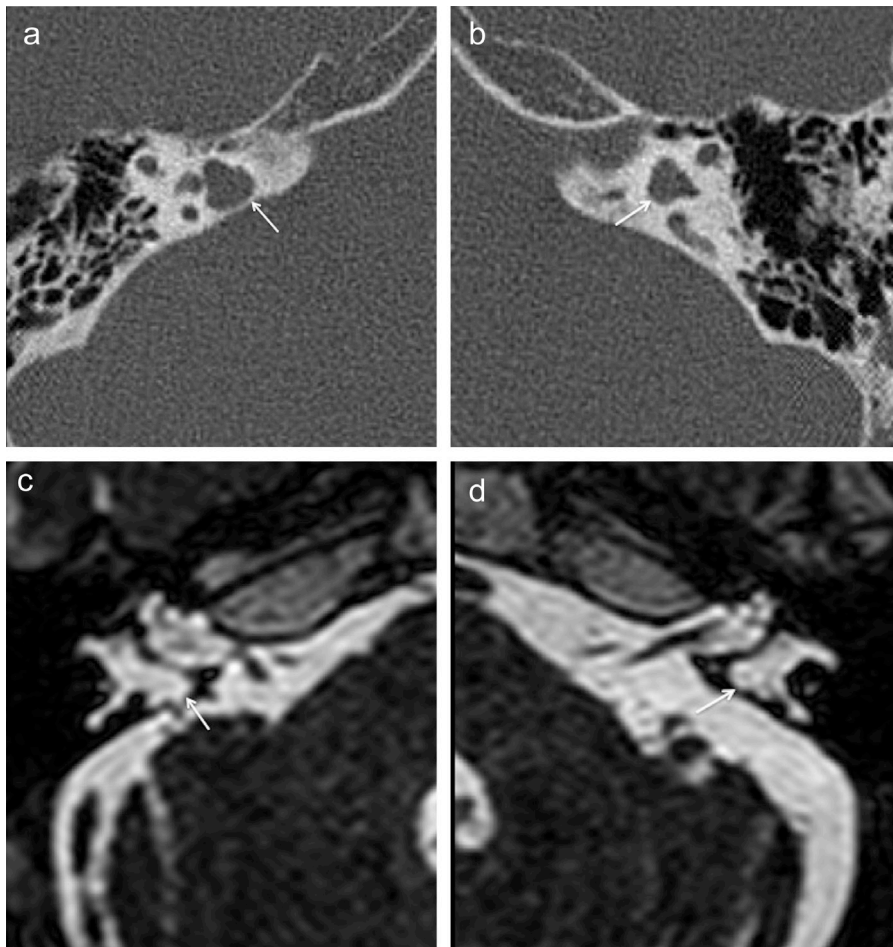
a-d. Bilateral cystic structures in the subarcuate fossa. CT image of a 47-year-old male patient with XLD (a, b). MR image (c, d) of a 53-year-old male patient with XLD in the same family as the patient in (a, b).
